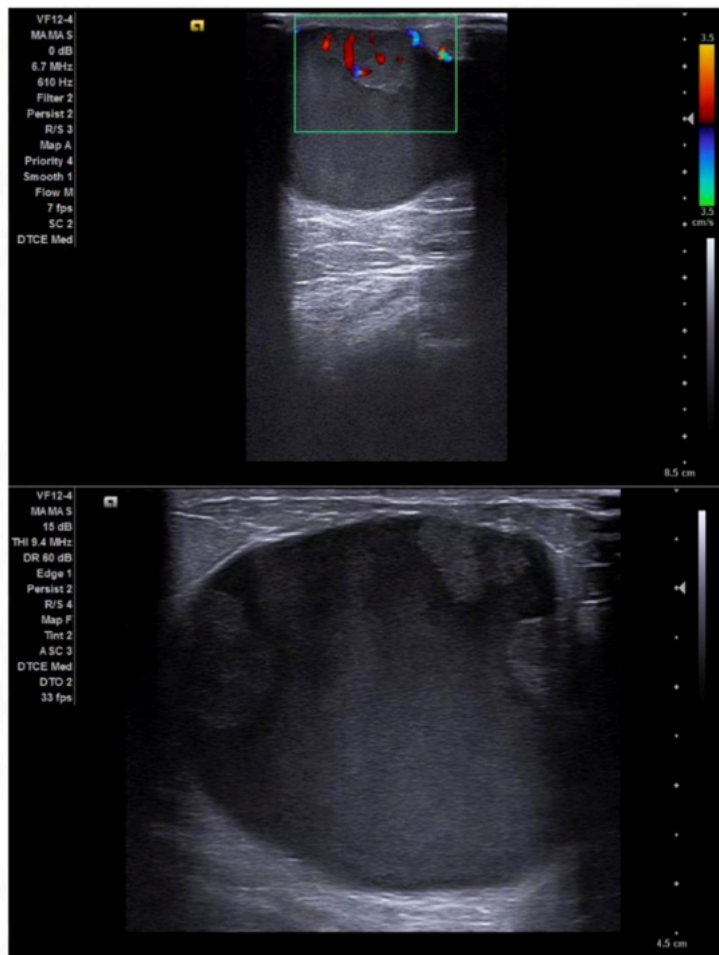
Right Breast US: Solid-cystic nodule, with fine echoes inside, showing flow on color Doppler in its papillary projections.
